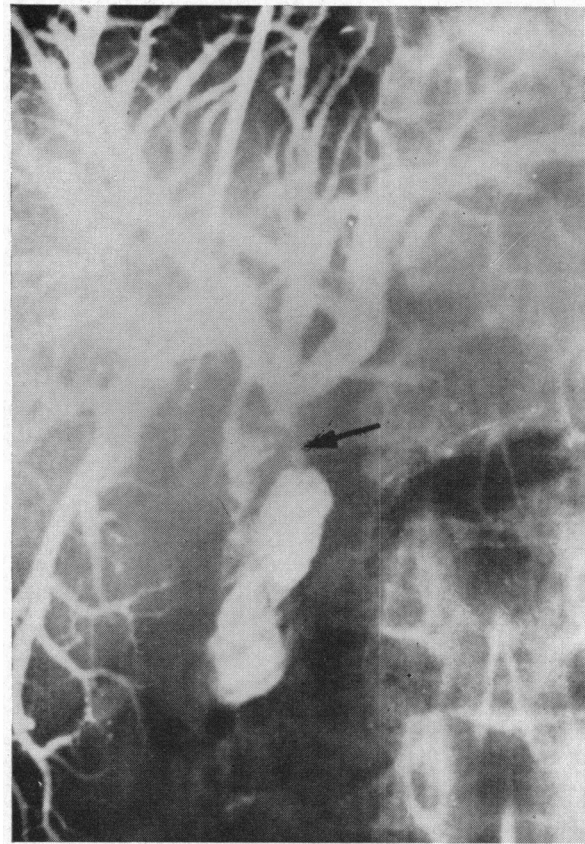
shows the radiographic studies in the case presented by Dr. Johnson. The upper gastrointestinal series shows some suggestive effacement and narrowing of the duodenal loop and some obliteration of the folds of the duodenum, suggesting a mass in the head of the pancreas. The cholangiogram reveals an enormously dilated intrahepatic ductal system. The arrow points to a sharp cut-off which we have come to recognize as characteristic of tumor. As was noted earlier, on surgical operation a fairly large carcinoma was found at the head of the pancreas.
